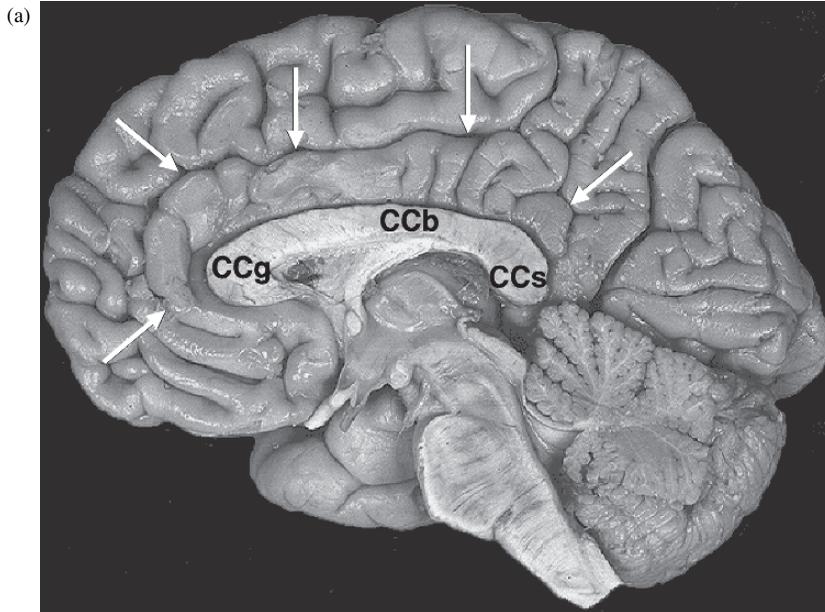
Cingulate gyrus as seen on (a) midsagittal brain section, on (b) midsagittal and (c) supracallosal axial MRI images. Cingulum can be seen on slightly more (d) parasagittal and (e) axial MRI images. Abbreviations: CCb, CCg, & CCs, the body, genu, and splenium of corpus callosum: CG cingulate g., Cg cingulum. Brain images were adapted from the *Interactive Brain Atlas* (1994), courtesy of the University of Washington.
